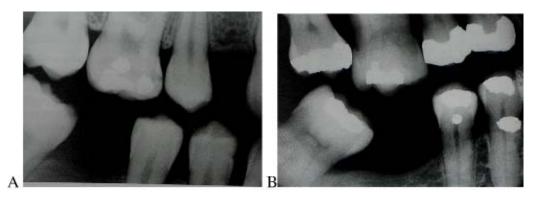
A bitewing radiograph showing caries in enamel and dental on the molar mesial (A) and distal (B) aspect of the upper first molar.
